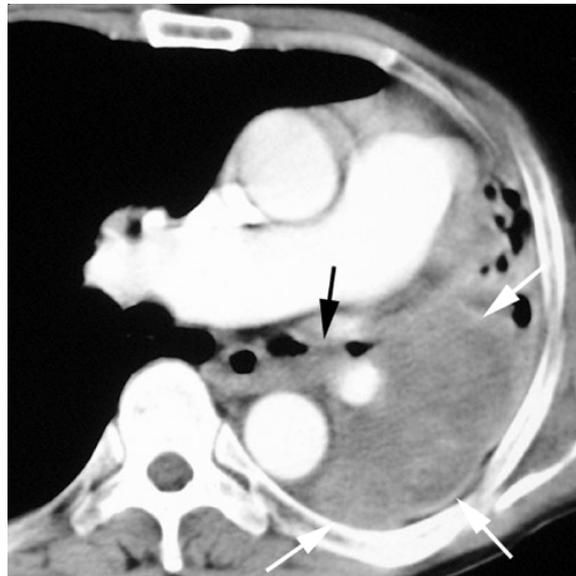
CT scan at the level of the right main pulmonary artery, shows a small endobronchial nodule in the left main bronchus (black arrow). Multiple masses are also seen (white arrows)
